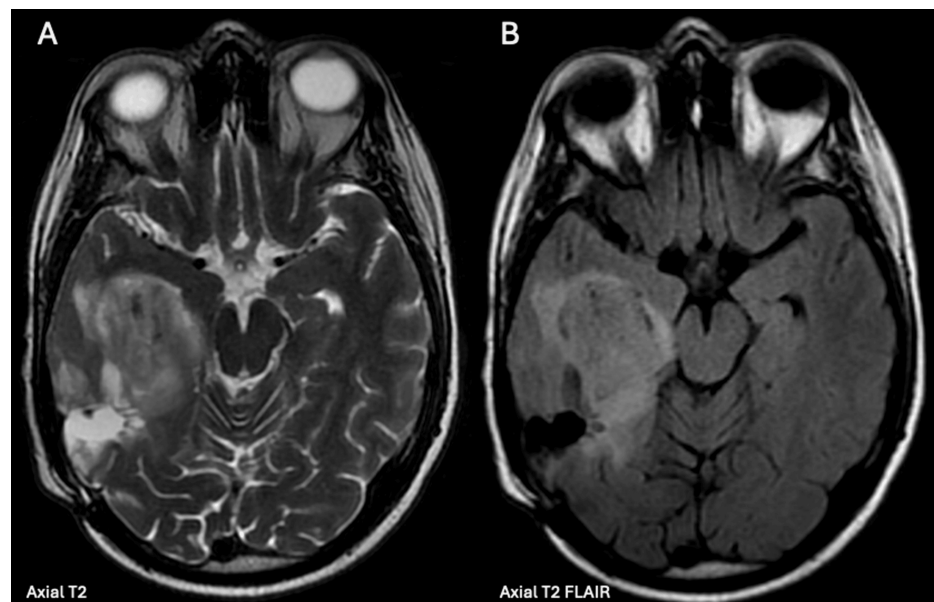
Brain MRI from August 2018
